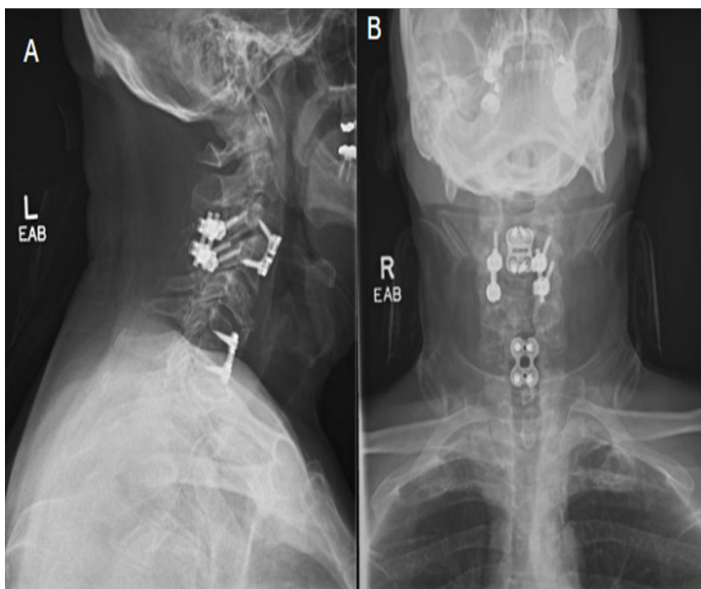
Post-operative sagittal cervical x-ray with prior C6-C7 ACDF and new C3-C4 ACDF.
